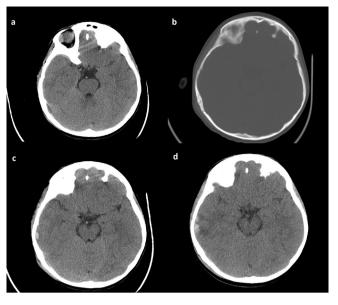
Right temporal linear fracture without parenchymal hemorrhage diagnosis at first admission (a,b). Cerebral contusion near the fracture was detected on control tomography at 6th hour(c). Additional cerebral edema and enhancement of contusion area on 3rd CT (d).
